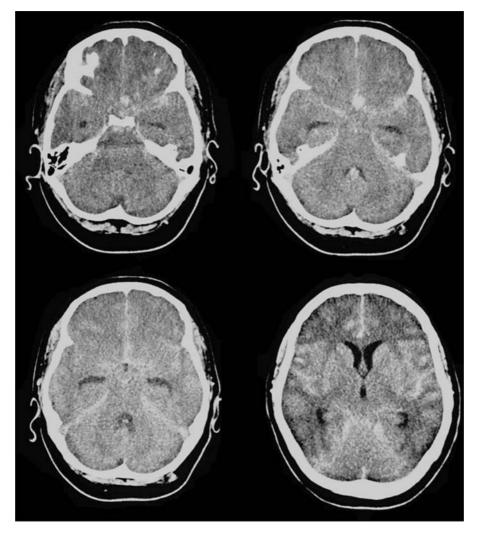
CT scan images showing subarachnoid haemorrhage Fisher grade III
